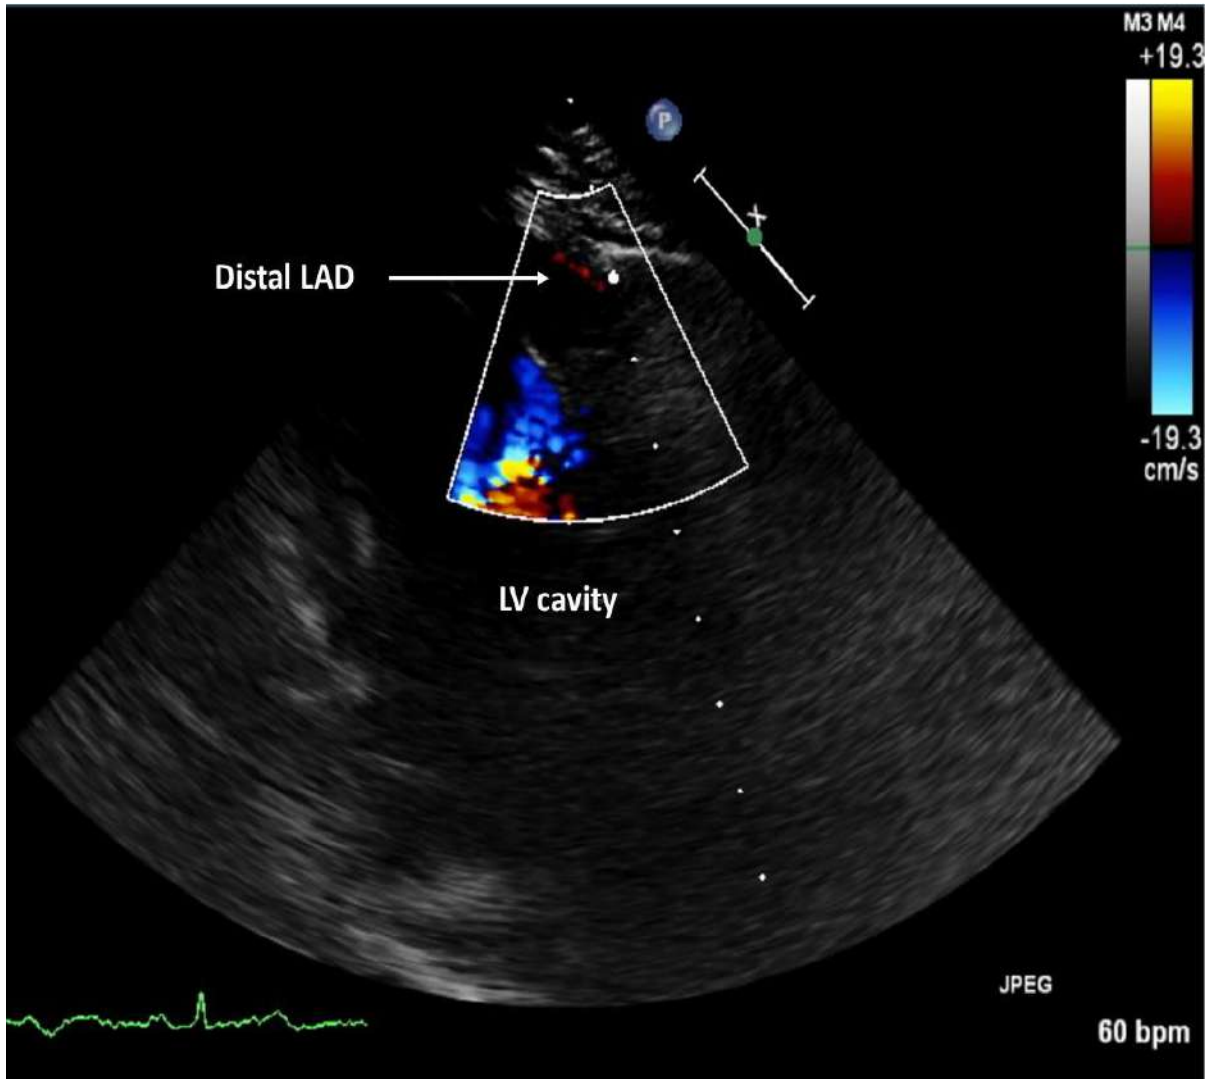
Colour flow Doppler identifying the distal left anterior descending artery. LAD – left anterior descending artery, LV – left ventricular.
